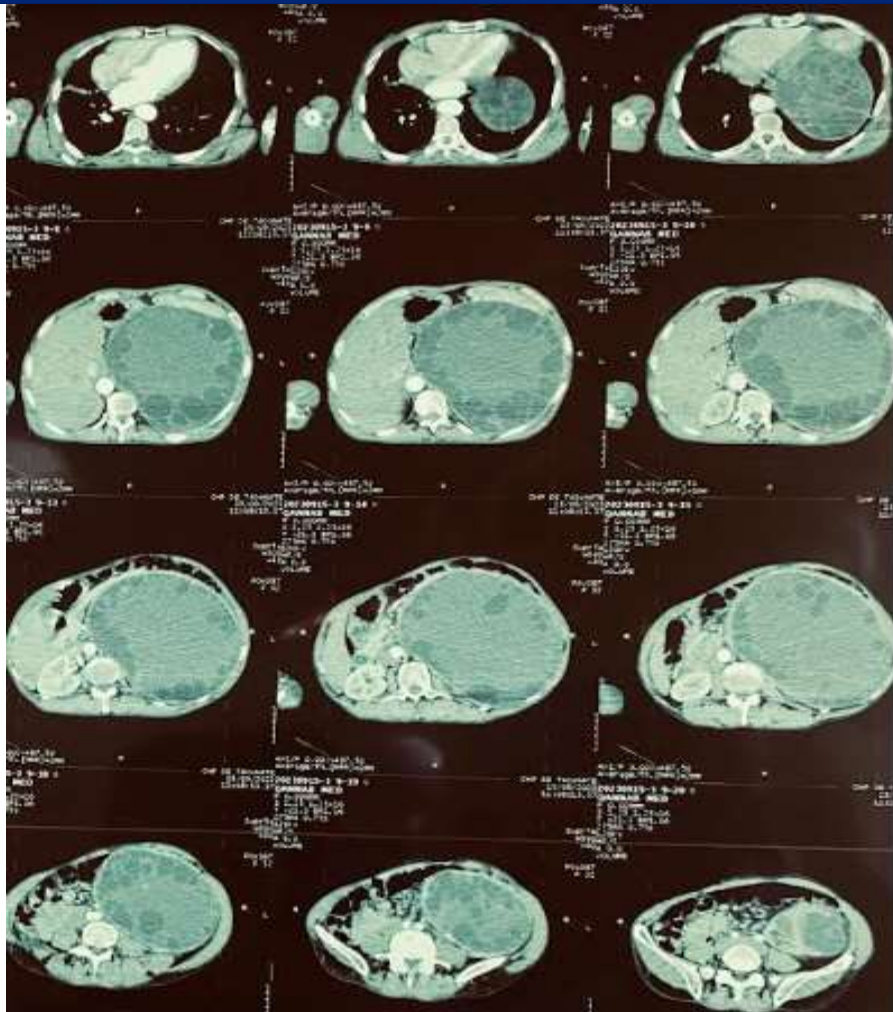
Axial CT image showing a left renal hydatid cyst.
